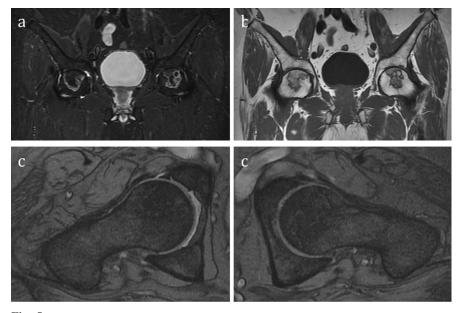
Coronal STIR-, coronal T1- and axial T2-weighted images; bilateral osteonecrosis of the femoral head.
